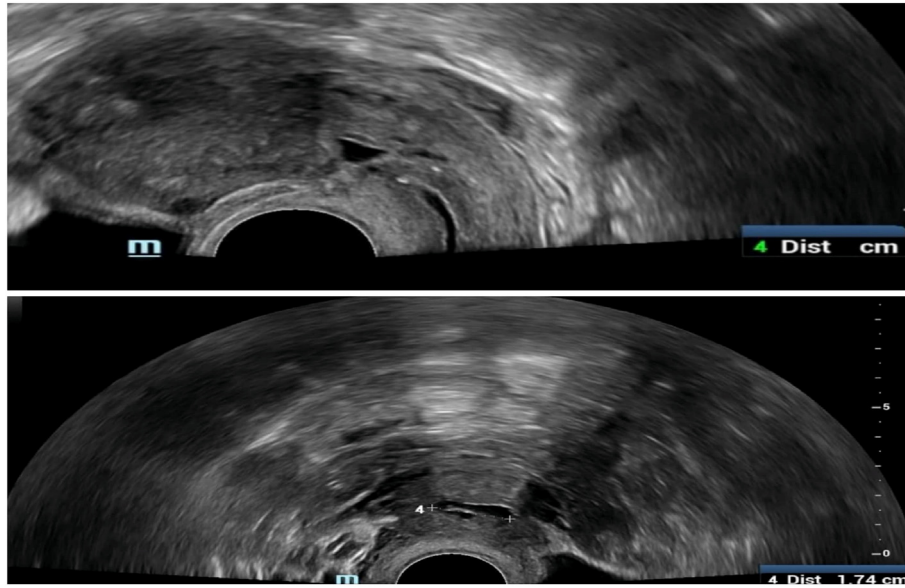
CSD in midsagittal (upper) and transverse (lower) view by TVS. CSD, cesarean scar defect; TVS, transvaginal sonography.
